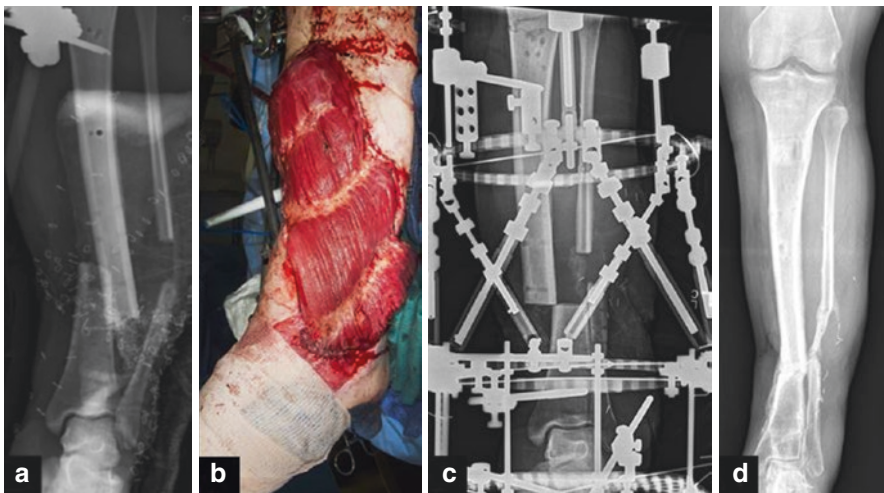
An AP radiograph of a severe open lower extremity fracture with significant bone loss that underwent acute shortening (a), which was performed in conjunction with a free flap (b) due to the combined bone and soft tissue loss. Distraction osteogenesis was then performed with a ringed external fixator (c) to achieve restoration of limb length and alignment (d)
